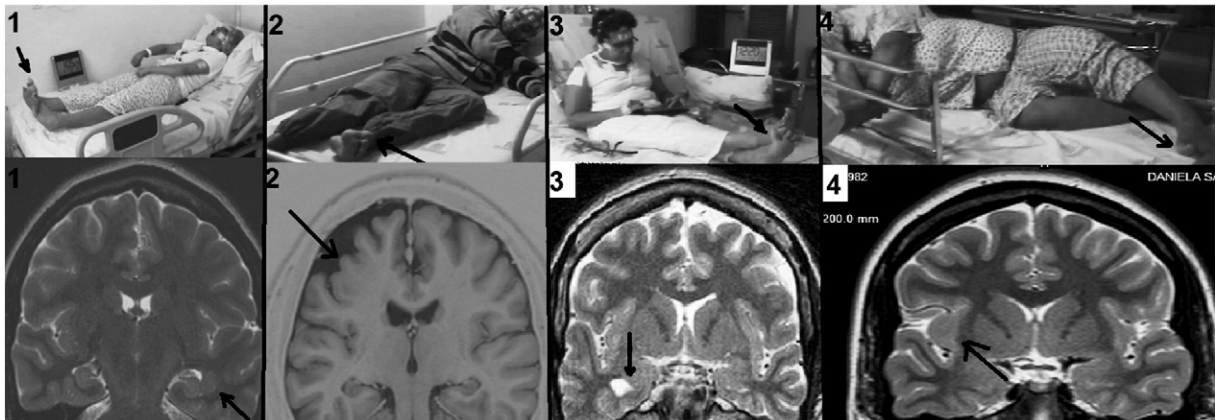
Dorsiflexion of the great toe in different patients of our series. Black arrow indicates the sign and in the MRI images, the lesion; patient 1 (left nodular periventricular heterotopia), patient 2 (right frontal cortical dysplasia), patient 3 (right hippocampal sclerosis) and patient 4 (right insular tumor).
